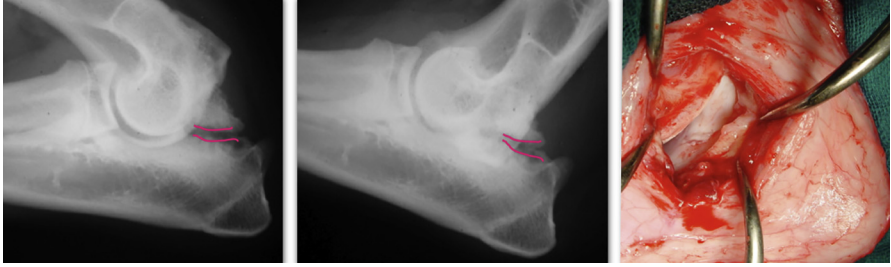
UAP stage II. The process is not fused and moves slightly. It is hinged at its caudal part, creating a small cranial gap. The joint is usually incongruent, with a shorter than normal ulna. Radiographically, the separation line has a complete radiolucent zone, increased in the extended view under pressure by the humeral condyle, but the process seems to be in place. Intraoperatively, it is possible to appreciate minimal mobility by means of palpation or by flexion–extension of the joint, and the anconeal process still seems to be in good condition, partially connected to the ulna.
